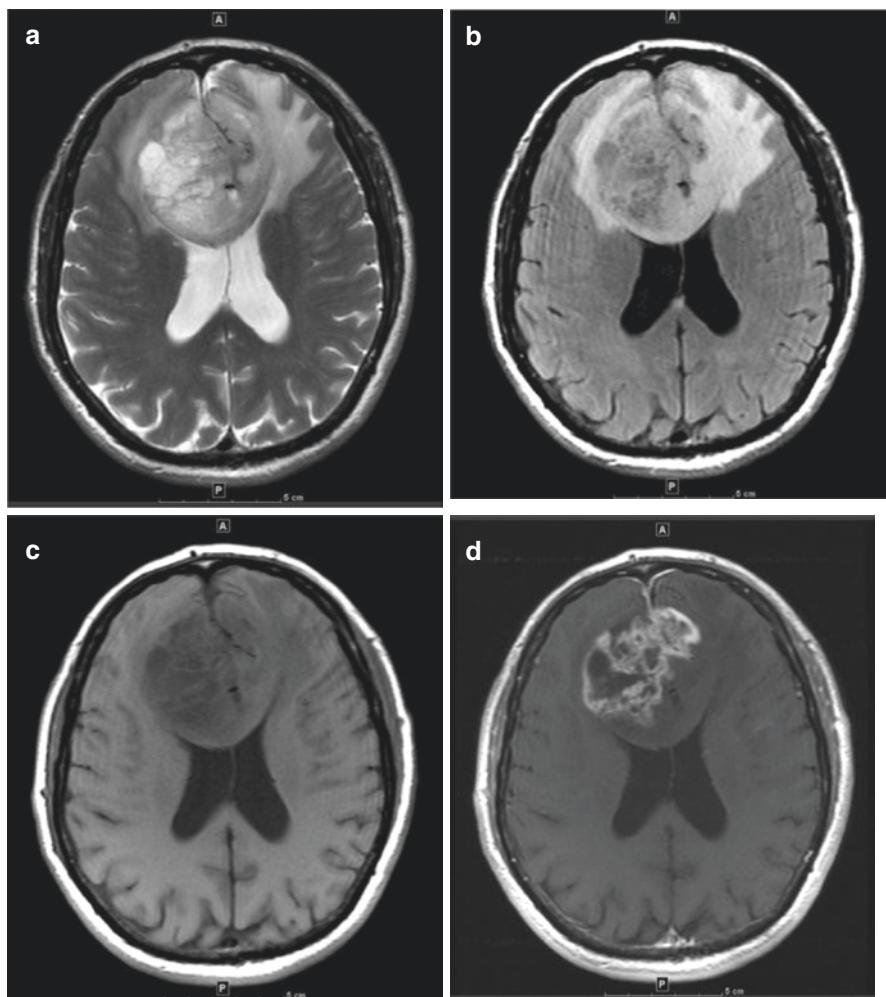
Selected axial MR images of a 78-year-old patient with a large glioblastoma in bilateral anterior frontal lobes and spreading across the anterior corpus callosum (butterfly lesion). (a) T2WI shows the multicystic tumor and mass effect on the lateral ventricles. (b) Better delineation of the surrounding vasogenic edema on FLAIR T2WI. (c) T1WI. (d) Irregular heterogeneous thick nodular enhancement on a post-contrast T1WI. (e) Patchy increased susceptibility effect (signal dropout) on GRE, suggesting minimal intratumoral hemorrhage. (f, g) Patchy tumor restricted diffusion on DWI (f) and confirmed as dark signal on the ADC map (g). (h) Increased cerebral blood flow in the anterior aspects of this tumor seen on bolus perfusion imaging
